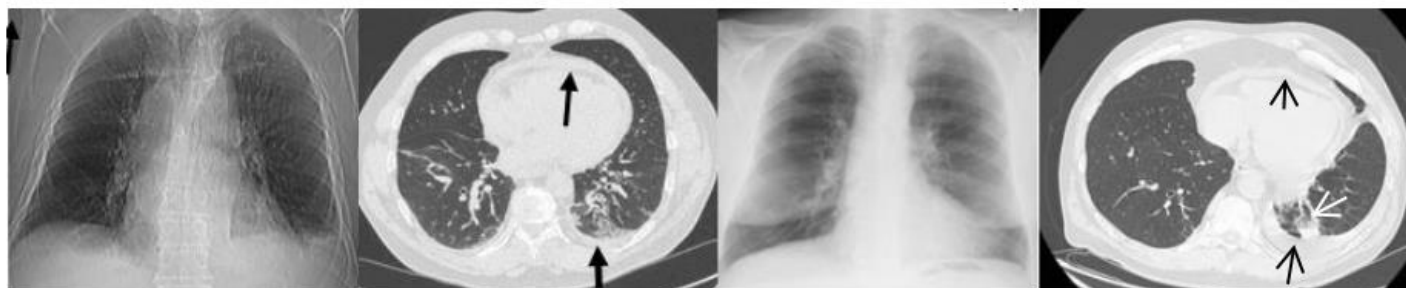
shows chest X-ray images and serial chest computed tomography (CT) scans of the lungs obtained during successive hospitalizations from 7 March to 30 December 2024.
